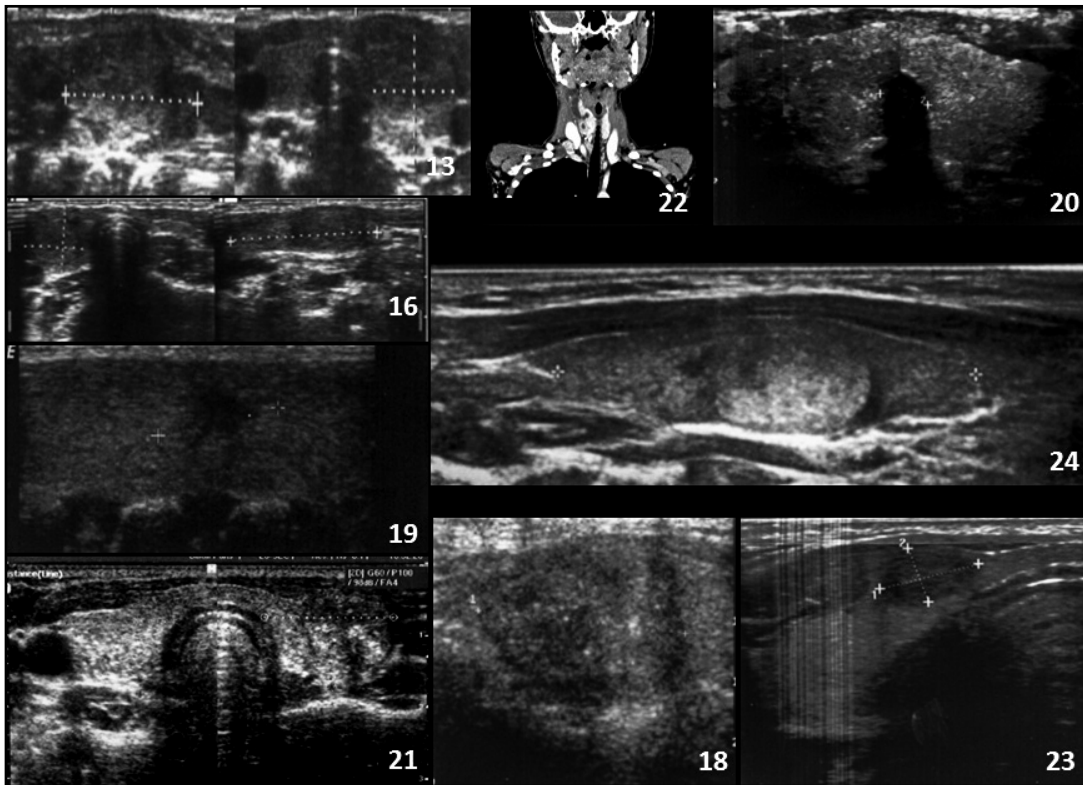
Ultrasound features of PTC in AIT(-) patients.
